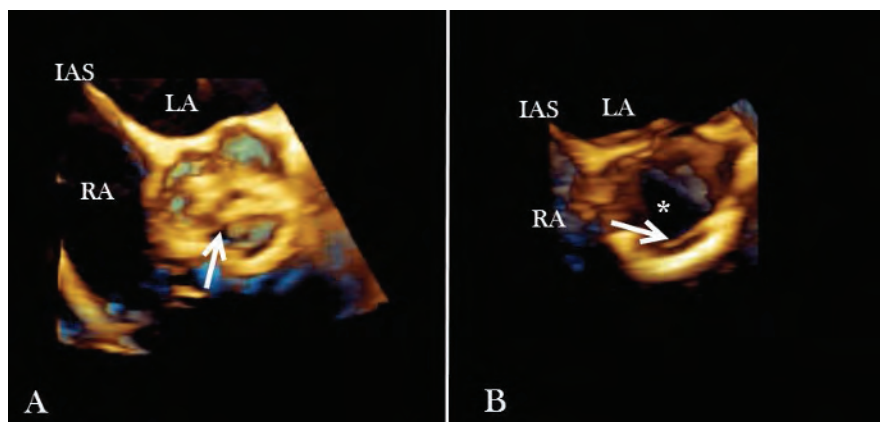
Three-dimensional transesophageal echocardiography of aortic valve in short axis. (A) Severe aortic stenosis of a tricuspid aortic valve during systole. (B) The same patient following deployment of a SAPIEN (Edwards Lifesciences, Irvine, CA) transcatheter aortic valve. Image obtained during systole. *Aortic valve orifice in systole following transcatheter aortic valve replacement. Arrow, native valve leaflet in panel A and bioprosthesis leaflet in panel B. IAS, interatrial septum; LA, left atrium; RA, right atrium.
